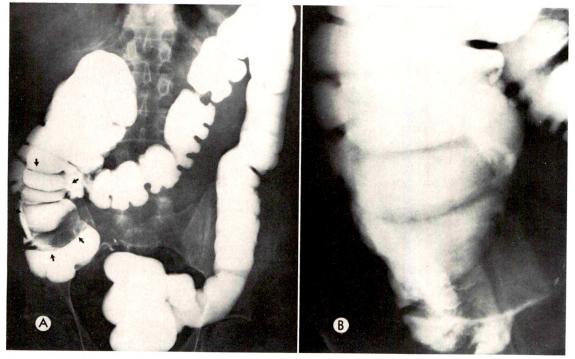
(A) A large smooth-bordered ascending colon mass is seen in the barium filled colon. (B) Radiolucency in the mass is not appreciated on a spot roentgenogram.
